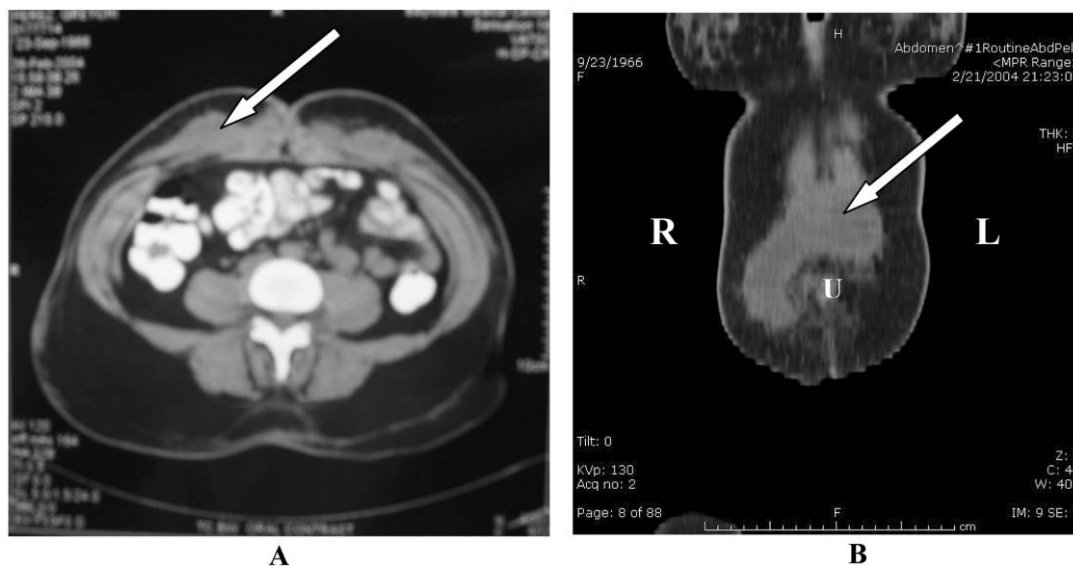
Abdominal CT for patient 1. *A*, Axial section showing *Mycobacterium abscessus* anterior abdominal wall abscess. *B*, Coronal section showing a horseshoe-shaped abscess extending from above the umbilicus to the right lower quadrant of the abdomen. L, left; R, right; U, umbilicus.
